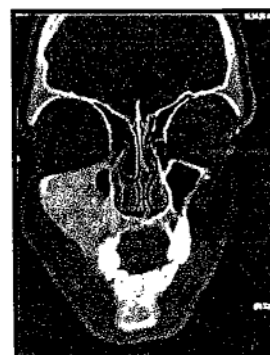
CT-Coronal view showing diffuse increase in radiopacity affecting right side of maxilla and maxillary sinus
